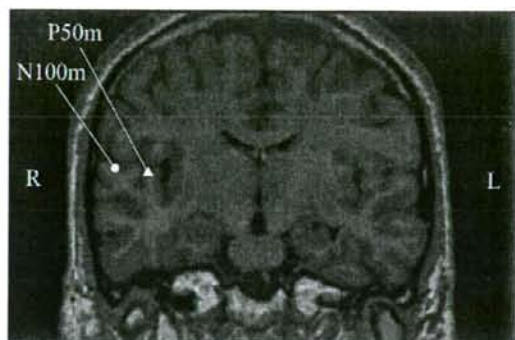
The locations of the P50m and the P100m sources in the right hemisphere of one subject projected onto the appropriate coronal MRI sections. The triangle signifies the P50m and the circle signifies the N100m. The P50m is located in the Heschl's gyrus and the N100m is located in the Planum Temporale. For this subject, the location of the N100m source is 1.36 cm lateral, 0.18 cm superior and 0.15 cm posterior to the P50m source.
